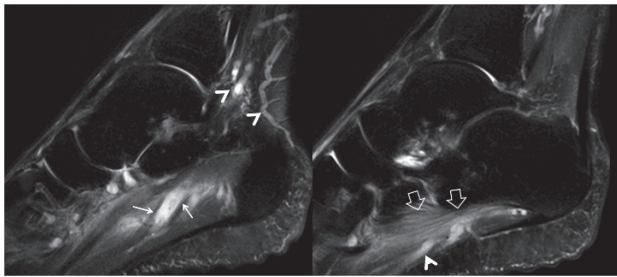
Sagittal fat suppressed T2-w MR images showing the varicose lateral plantar vein with tiny filling defects (arrows) and the oedematous quadratus plantae muscle (open arrows). Additional varicose veins are shown (arrowheads).
